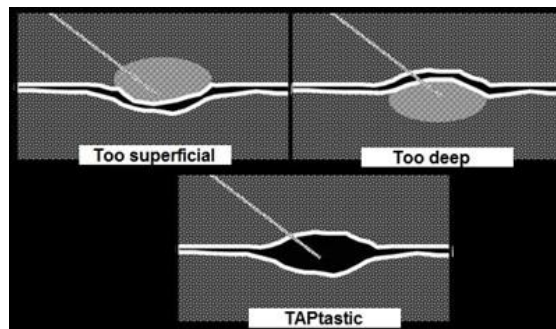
The optimal needle position during ultrasound-guided TAP block
